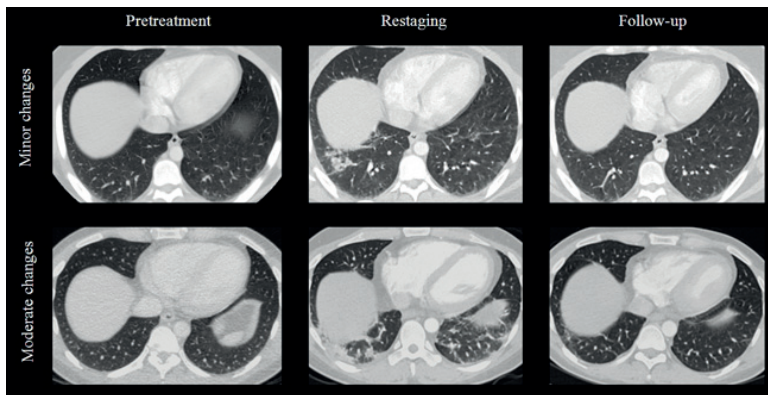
Representative examples of minor graded (upper panel) and moderate graded (lower panel) bleomycin-induced pulmonary changes; pretreatment, restaging and follow-up CT scan (left to right).
